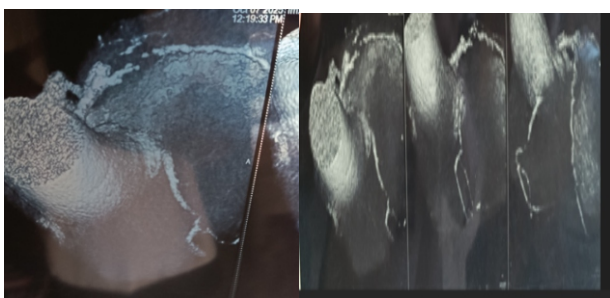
CT coronary angiography with near total obstruction of proximal segment of Left anterior descending artery.
